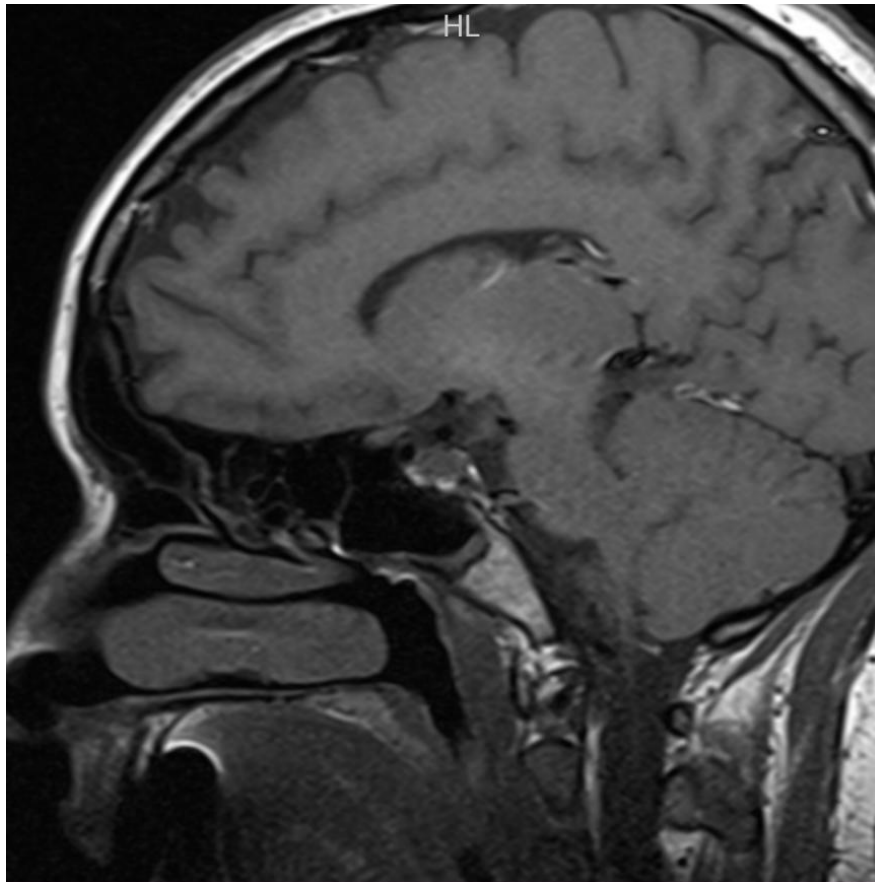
MRI - Signal heterogeneity in the adeno pituitary gland, corresponding to the sequelae of pituitary apoplexy (pituitary necrosis)
